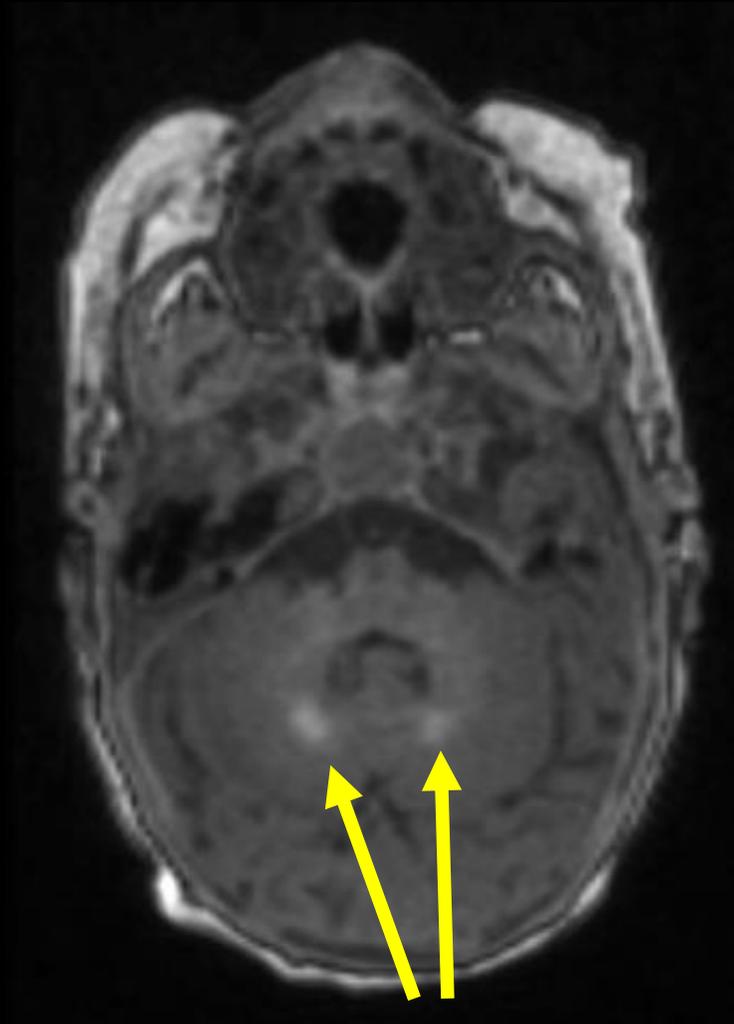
MRI Brain Axial T1-weighted. Intraparenchymal T1 hyperintensity within cerebellum (left) the bilateral amygdala (right)
